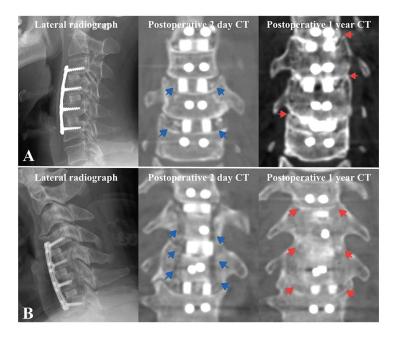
Construct comparison between vertebral body sliding osteotomy (VBSO) and anterior cervical discectomy and fusion (ACDF). (A) Lateral radiograph demonstrates 3-level ACDF with anterior plating which provides multi-point fixations. Although local auto bone grafts are inserted at the disc spaces (blue arrows), multiple cortical discontinuity (red arrows) are observed despite bone bridge formation at 12 months follow-up CT. (B) Lateral radiograph demonstrates 2-level VBSO involving 3-level discectomies. Bone grafts are inserted longitudinally along the lateral slits in VBSO (blue arrows). More abundant bone bridge formation with continuous cortical density (red arrows) is observed in 12 months follow-up CT.
